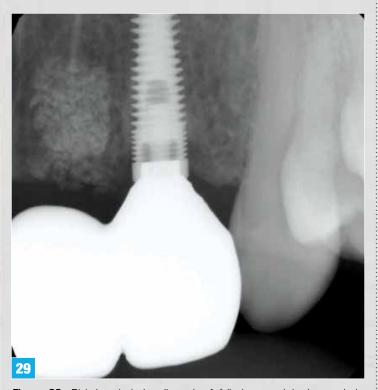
Digital periapical radiograph showing one of the fully seated final zirconia abutments.
